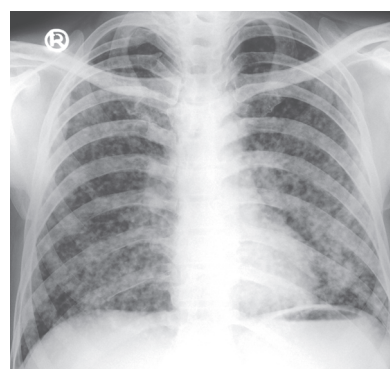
Chest radiograph in PA projection shows miliary opacities in both lung fields in a case of tubercular pneumonia.
